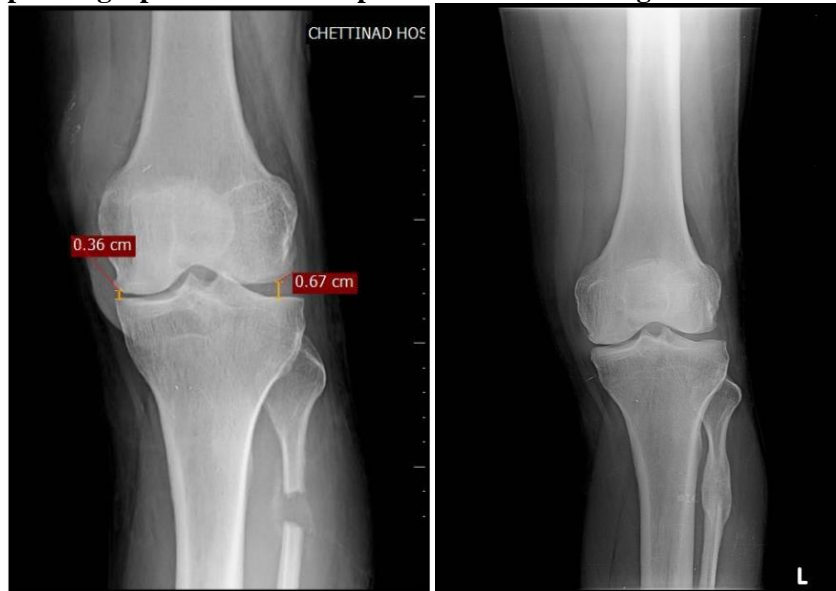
Pre- OP RadiographFigure 3: Post-op radiographs with follow-up at 15 months showing union of fibula
